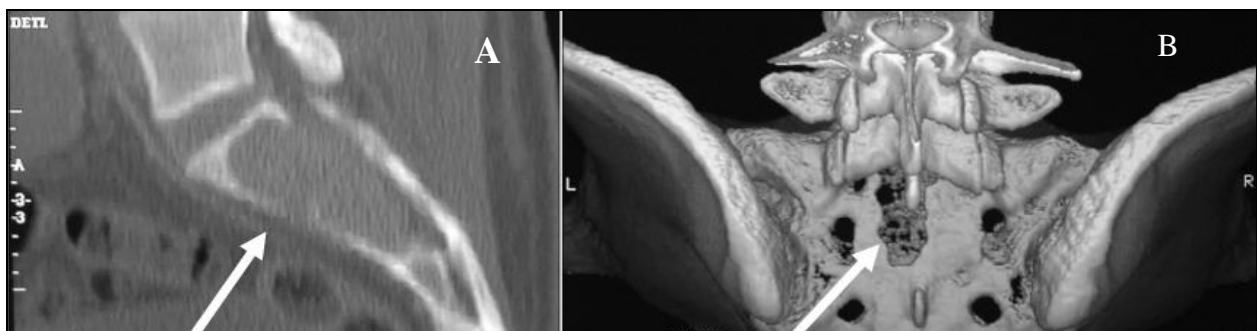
(A,B). CT scan images showing (A) Campanacci III lesion extending into the neural canal posteriorly from sacral segments S1 and S2 (arrow). 3-D reconstruction of sacrum viewed from behind (B) demonstrating previous left S1 laminectomy (arrow)
